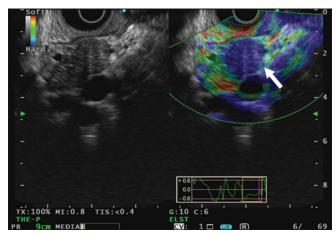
Endoscopic ultrasound: A hyper-enhanced lesion (white arrow) measuring 10.7mmx 19.3mm, with iso-echoic characteristics and a blue elastography pattern, at the pancreatic haed
